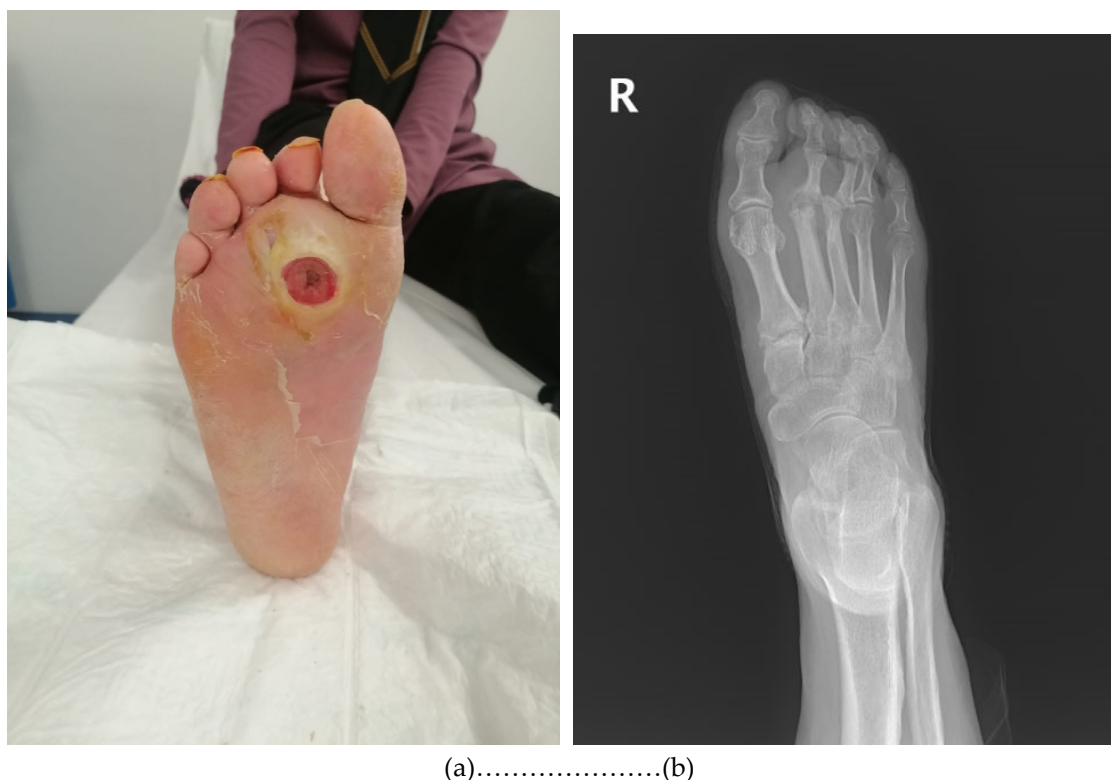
(a) A diabetic foot ulcer on the plantar surface with a positive probe-to- bone test, consistent with osteomyelitis. (b) Same patient, X-ray image consistent with osteomyelitis. Phalanges and metatarsal bones show osteolytic lesions, cortical erosion, and irregularities.
